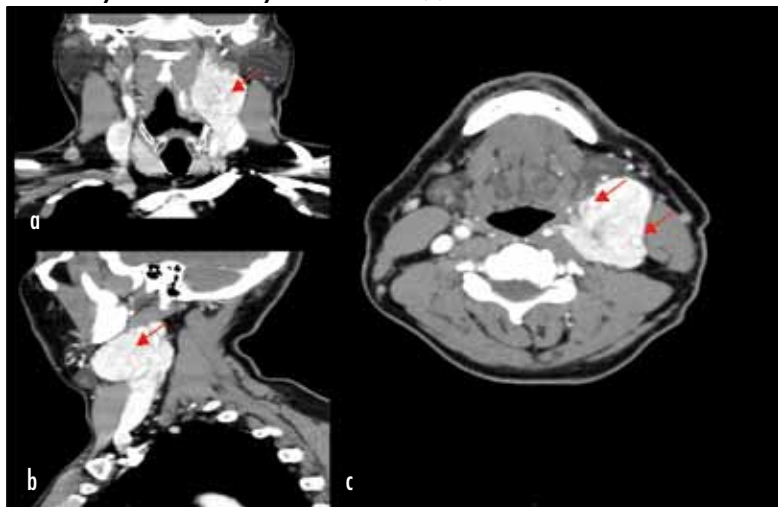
Computed tomography neck (coronal, sagittal and axial). a and b. Left-sided carotid body tumour intimately associated with (c) internal and external carotid arteries.
